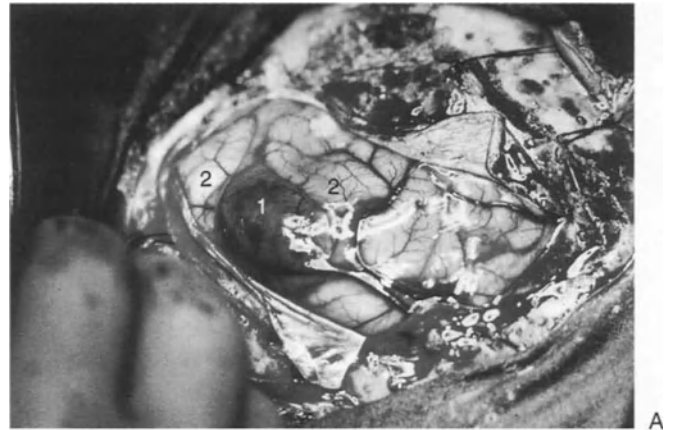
(A) This highly vascularized, well-circumscribed mass was resected by working around the periphery of the tumor where it borders normal cerebral tissue, after having occluded the main feeding vessels. The bridging vascular structures between the tumor and surrounding tissue were coagulated and transected as the dissection proceeded freeing the tumor (1) completely from the surrounding cortex and white matter (2). The two axial MRI scans (B) and (C) are respectively T2 and T1 post-enhancement images of the cavernoma (considered for the purposes of this text to be a highly vascularized tumor).
